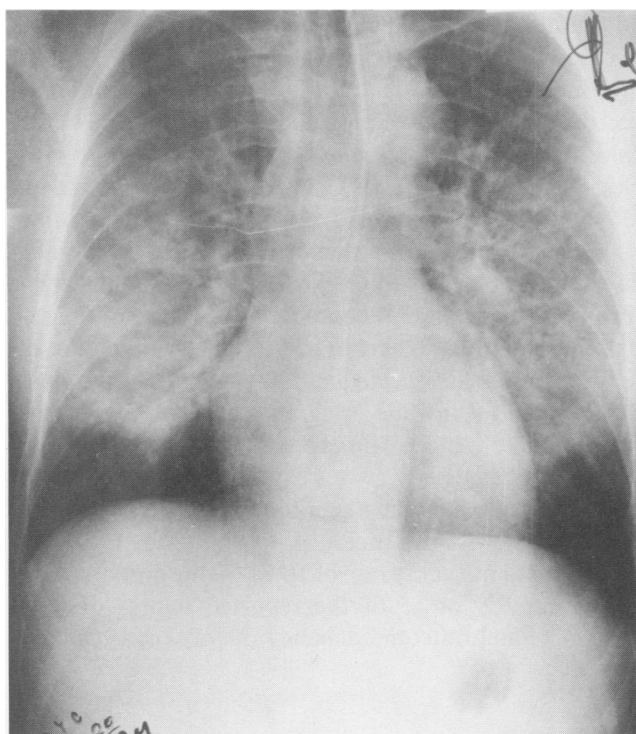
Chest x-ray (PA) of one of the patients with primary blast lung injury, 6 hours after the explosion. Note the bilateral patchy infiltrates. This patient had no signs of external chest trauma.
